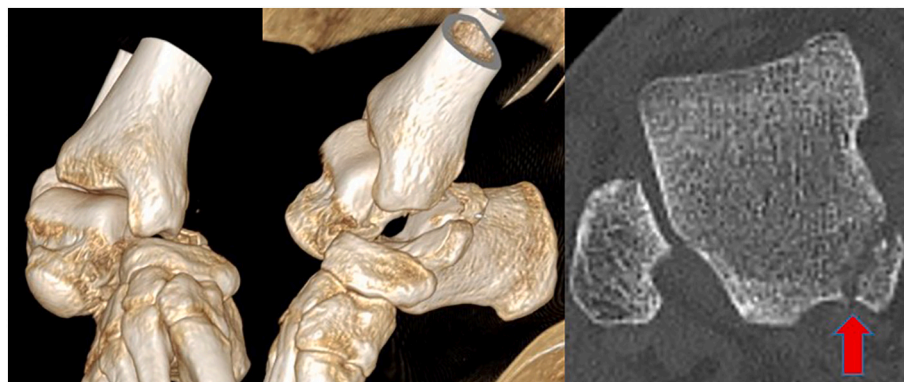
CT of the ankle and the foot with 3D reconstruction confirmed the diagnosis, but showed an associated undisplaced fracture of the posterior part of the talar bone (arrow).
